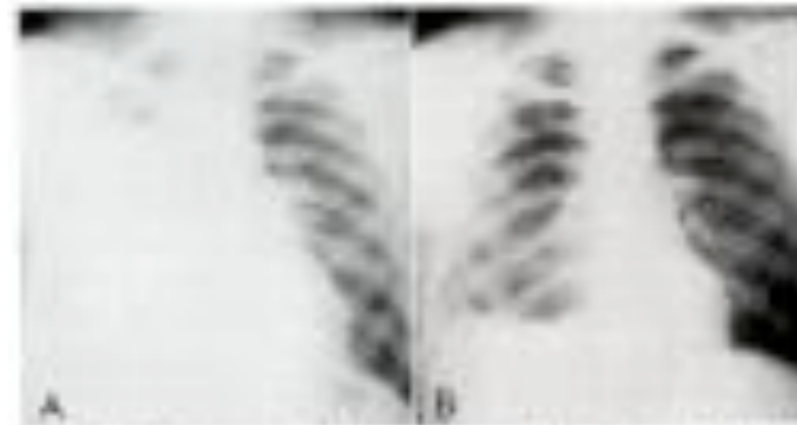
Roentgenograms of hemithoracic empyema by decortication. A. Preoperative roentgenogram shows a massive, homogeneous opacity of the right hemithorax. B. Shows it clear after primary decortication. Four-day postoperative roentgenogram and clear lung completely reexpanded and clear lung in position of normal expansion.
